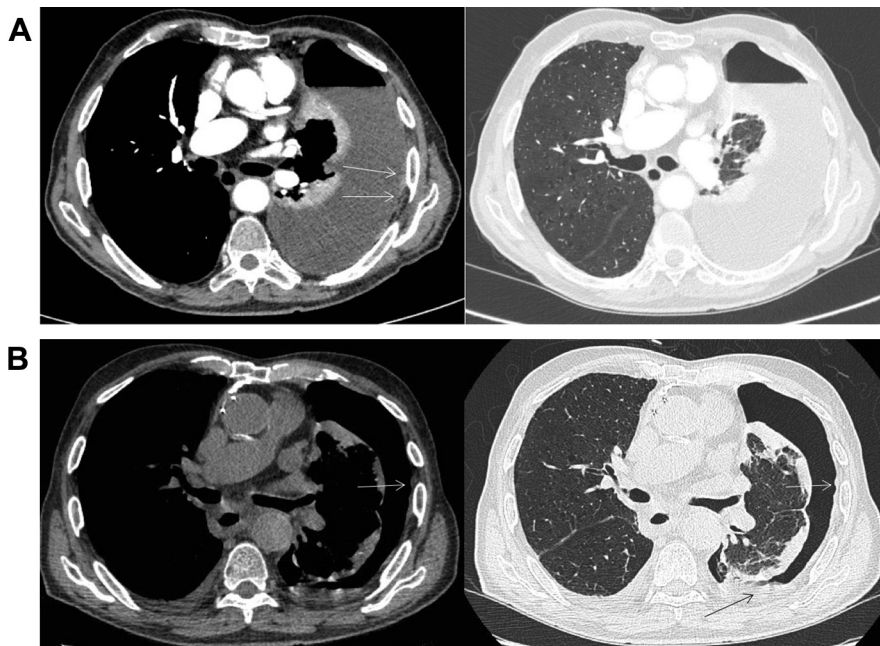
A, CT image showing barely perceptible pleural thickening (arrows) in the setting of large left-sided pleural effusion. B, CT image after drainage of pleural effusion with trapped lung. Air/pleural interface shows more clearly defined nodular pleural thickening (arrows).
